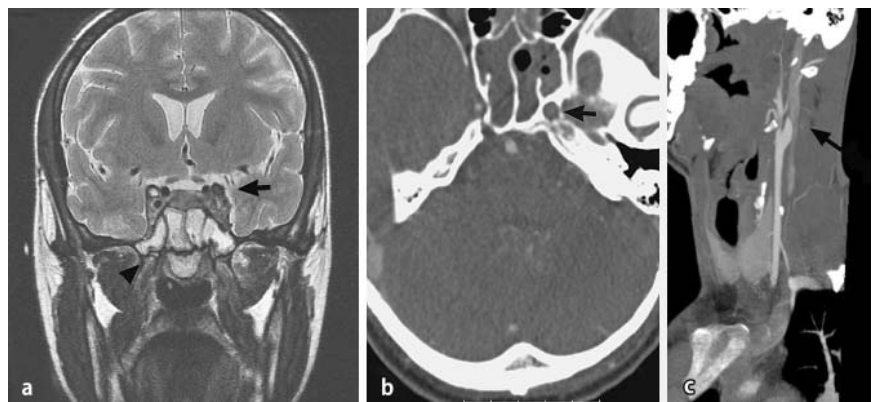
a T2W MRI: occlusion of cavernous part of left ICA (arrow), loss of liquor content of left cavum Meckeli due to debris, loss of pneumatisation of sphenoid en ethmoid sinus (arrowhead). b CT angiography: left sided ICA occlusion (arrow) and right sided ICA stenosis. Loss of pneumatisation of sphenoid sinus. c CT angiography after 9 months: ICA occlusion just distal from the bifurcation
